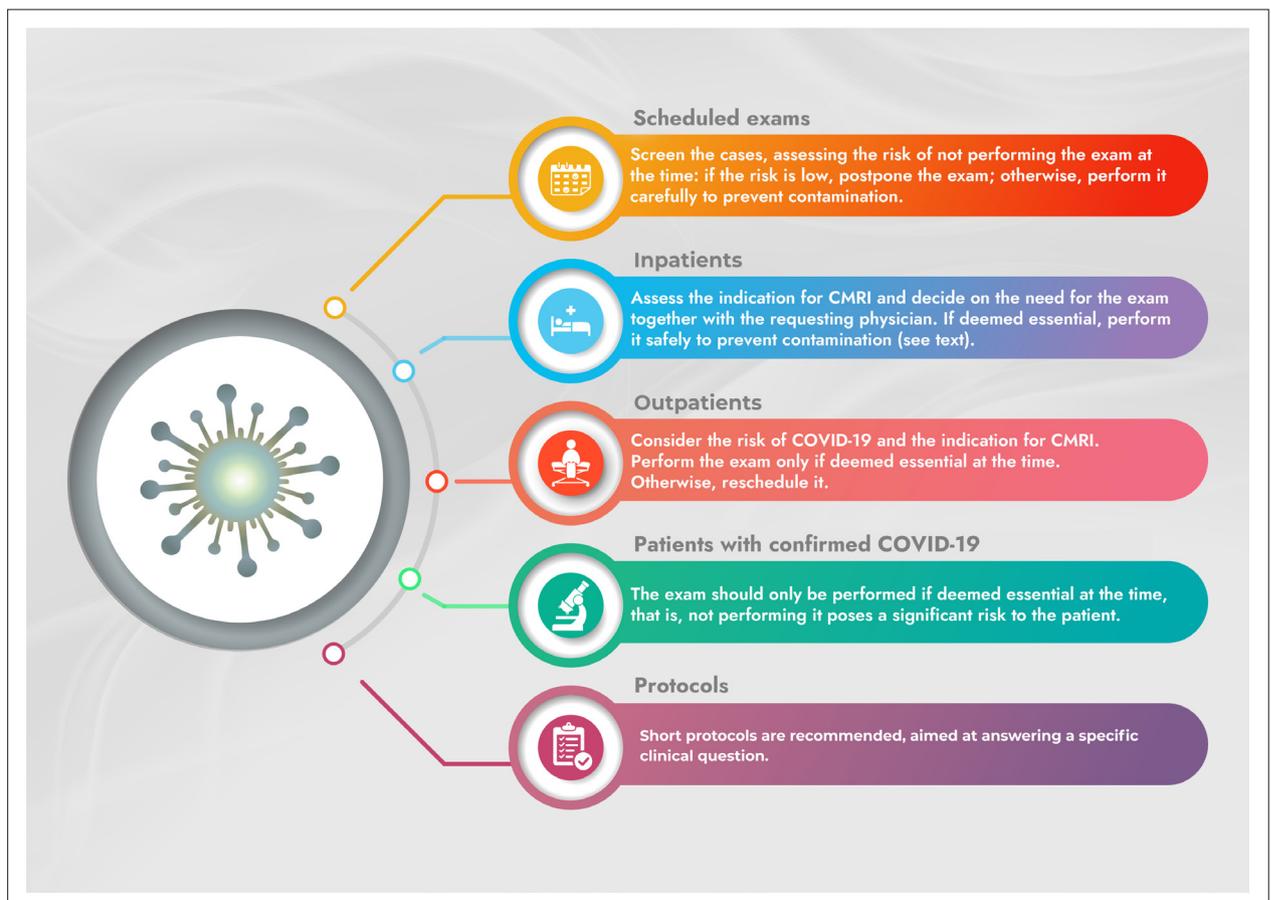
Recommendations for performing cardiac magnetic resonance imaging (CMRI) during the COVID-19 pandemic.
